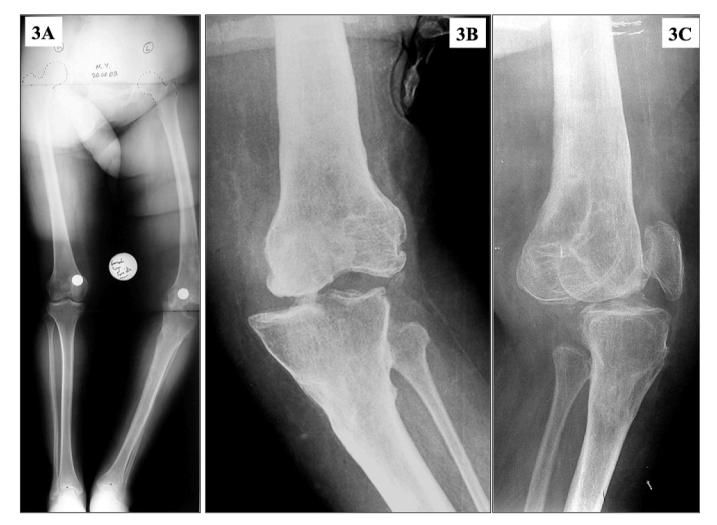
AP standing full-length lower extremity (3A), standard AP (3B) and lateral radiographs (3C) of Case 1 at presentation is consistent with Mullaji type 2 instability.
